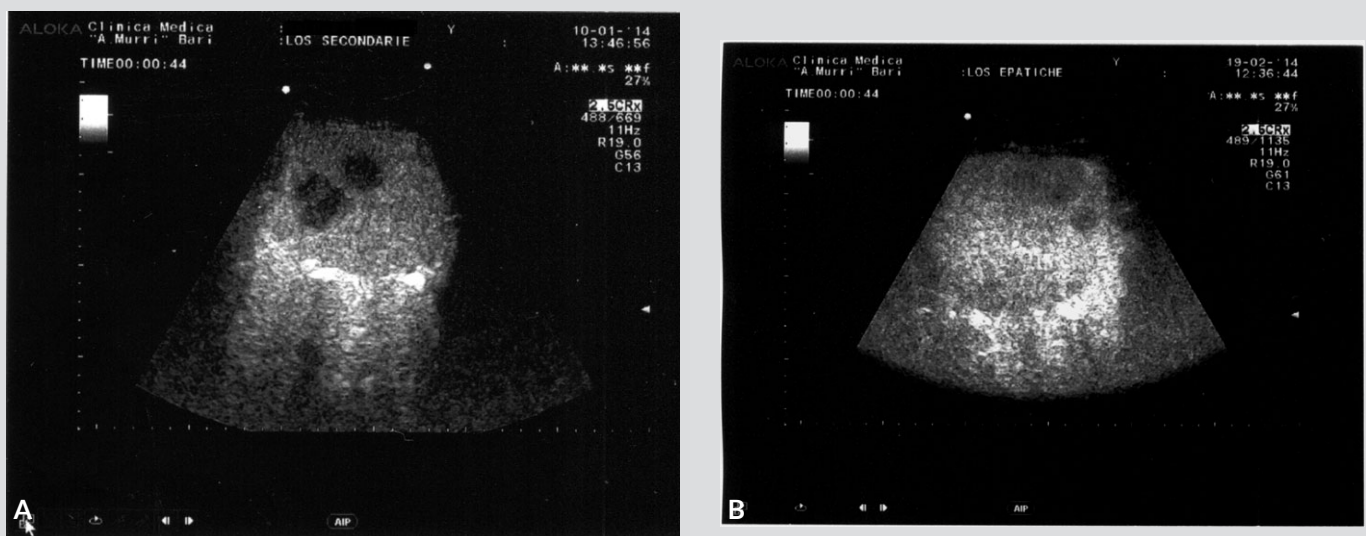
Contrast-enhanced ultrasound examination (CEUS). A: Before treatment, the image shows that the lesions are hypoechoic in the late phase of the examination. B: after treatment: the lesions have smaller size and appear lightly hypoechoic during the late phase of examination
